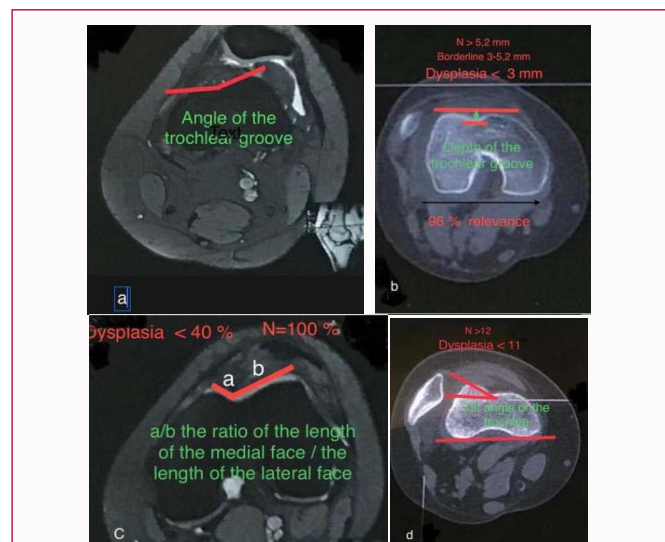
Diagnosis of trochlear dysplasia. CT evaluation, preferably MRI.
